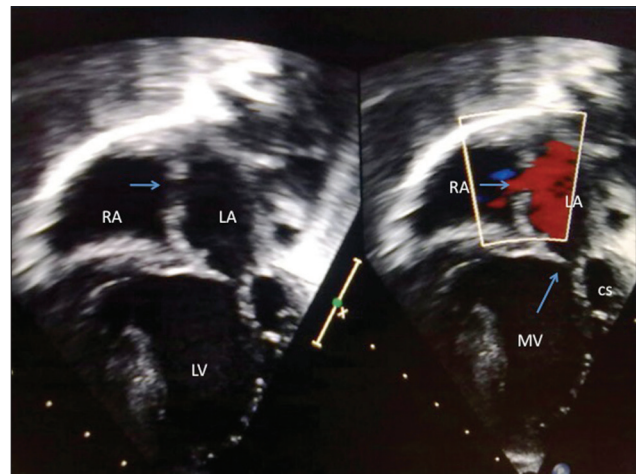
Pre-discharge transthoracic echocardiogram shows the atrial septal opening. Color Doppler (right frame) shows a laminar flow across the atrial septum
